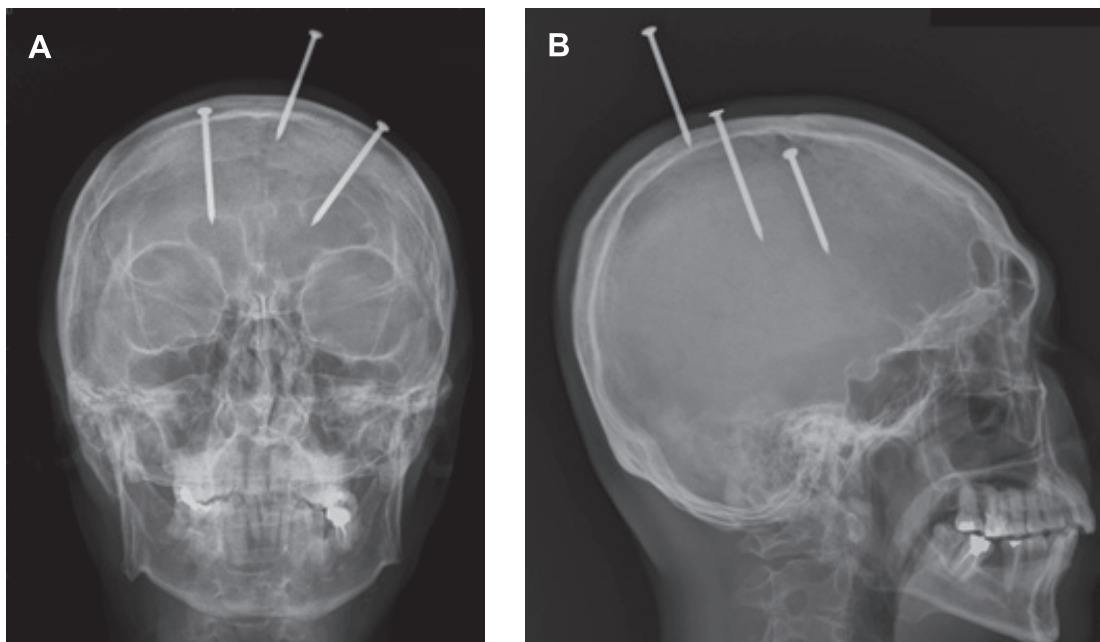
(A) Anteroposterior, and (B) lateral radiographs of the skull showing two 5 cm nails penetrating into cerebral parenchyma and one near the midline.
